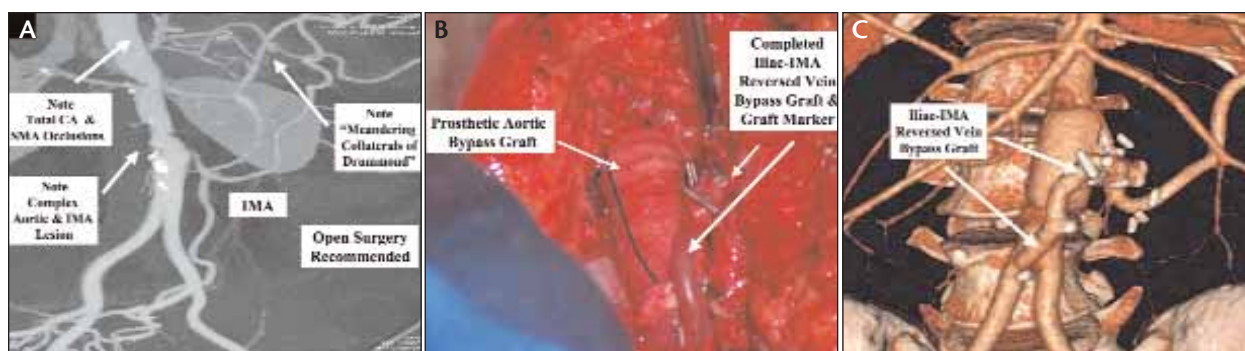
CTA in a patient with severe claudication, abdominal pain, 100% CA and SMA occlusion, with a complex, ulcerative aortic stenosis and 95% ostial IMA stenosis (A). Surgical bypass of the aorta and IMA was recommended on the CTA findings (B). CTA follow-up shows excellent interposition IMA graft patency (C). The entire diagnosis, treatment recommendation, and follow-up management were facilitated by PV-CTA.
